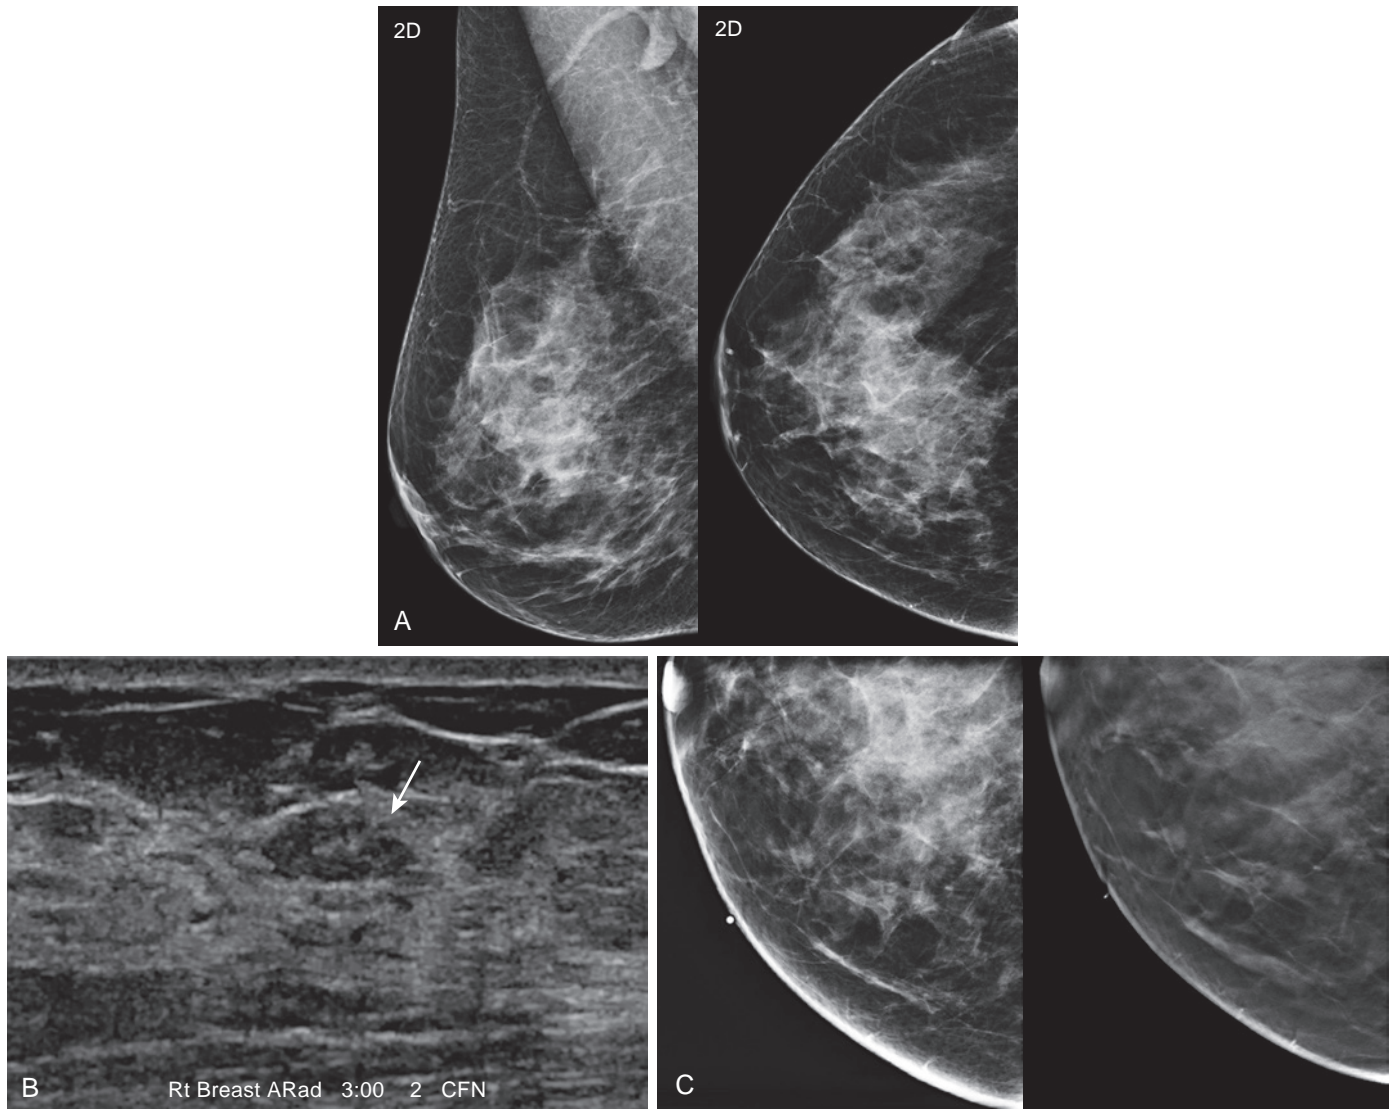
(A) A 30-year-old woman with a history of mantle radiation for non-Hodgkin's lymphoma 5 years earlier presented for screening. Tomosynthesis mammography shows dense tissue but no focal abnormality. (B) Screening ultrasound demonstrates a wider-than-tall, hypoechoic, 1-cm mass in the right breast at the 3-o'clock position (*arrow*). (C) A BB was placed on the skin over the sonographic abnormality, and a tomosynthesis spot view was obtained, which shows no definite abnormality. Due to her high-risk status, a biopsy was desired and revealed benign stromal fibrosis. A short-term follow-up would have also been appropriate.
